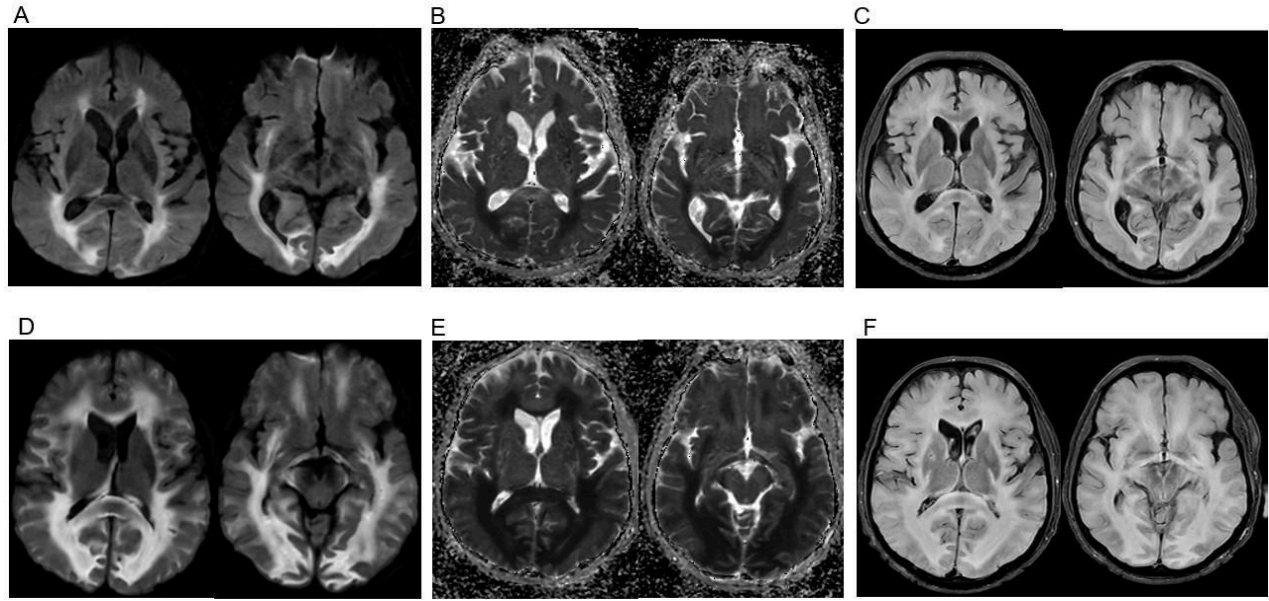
Axial MRI imaging from a 62-year-old male with leukoencephalopathy. (A-C) MRI images taken 20 days after HSCT showed (A) symmetrical restricted diffusion in the periventricular white matter on diffusion weighted imaging, (B) corresponding decreased signal on apparent diffusion coefficient imaging, and (C) diffuse FLAIR hyperintensities. (D-F) MRI images taken 29 days after HSCT showed (D) worsening restricted diffusion on diffusion weighted imaging, (E) decreased signal on apparent diffusion coefficient imaging, and (F) increased FLAIR hyperintensities.
